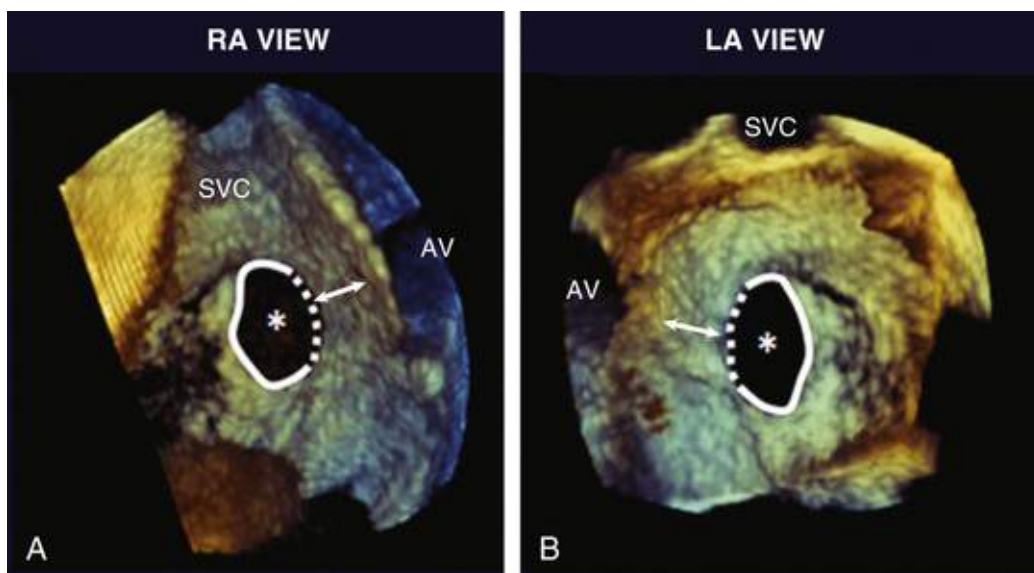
Assessment of ASD rims with 3D TEE in the A, right atrial (RA), and B, left atrial (LA), views. The anterior rim is represented as the distance between the *dotted line* and the aorta (*arrow*). AV, Aortic valve. (From Saric M et al. Imaging atrial septal defects by real-time three-dimensional transesophageal echocardiography: step-by-step approach. J Am Soc Echocardiogr 2010;23:1128.)
